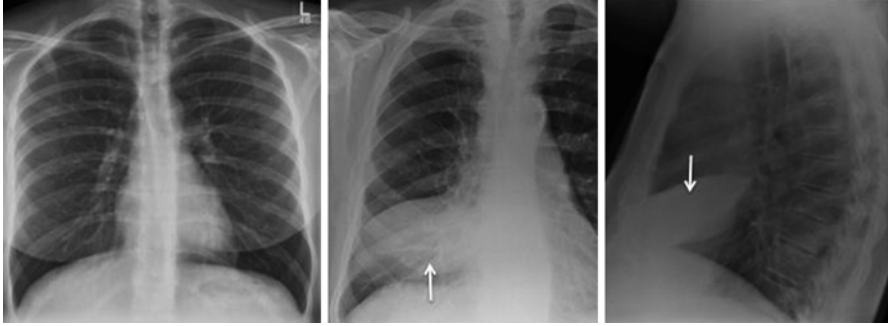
Silhouette sign: *Left panel* is a normal chest radiograph demonstrating the “silhouette” sign. The mediastinum, heart and diaphragm are sharply delineated against the aerated lung. Frontal (*middle*) radiograph in a different patient shows obscuration of the right heart border due to consolidation (*white arrow*) in the immediately adjacent lung (right middle lobe). On the lateral film (*right panel*) the consolidation (*white arrow*) has a straight margin as it abuts the fissure
